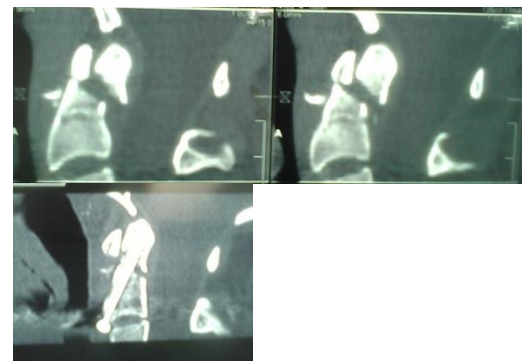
Pre and post operation X-ray of an 18 yr-old man with odontoid fracture due to car accident
